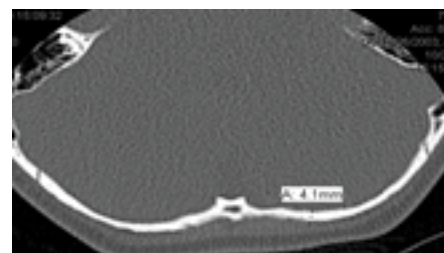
Non-contrast axial CT of the head demonstrating the thinness of the occiput (4.3 mm).
